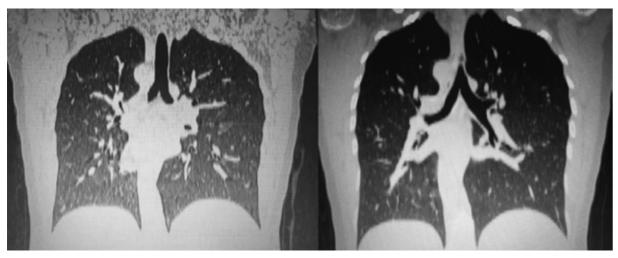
CT scans (sagittal view) of the right lung and right hilla.
